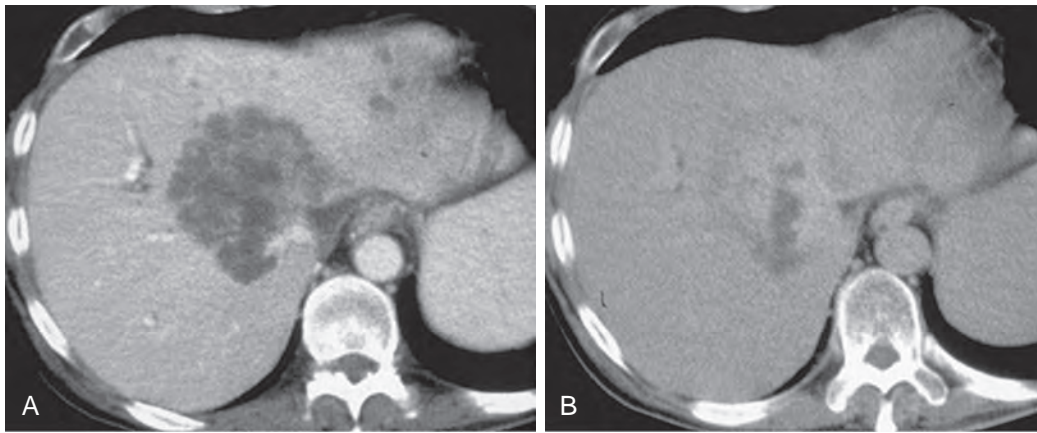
ICAC: CT features. A. This lesion does not enhance on the portal venous phase image. B. Significant contrast enhancement, with the exception of the central scar, is present on the 10-minute delayed scan.
